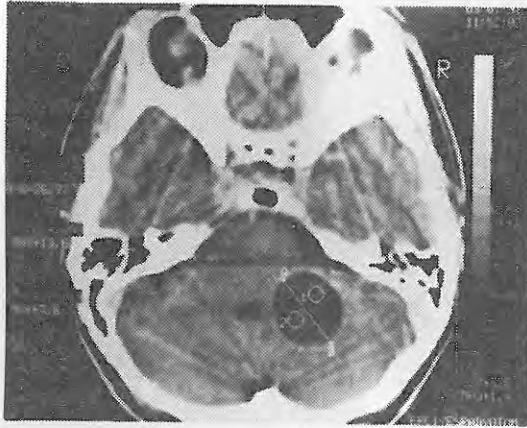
The first preoperative CT scan of the cerebellar hydatid cyst measuring 26.7 mm
